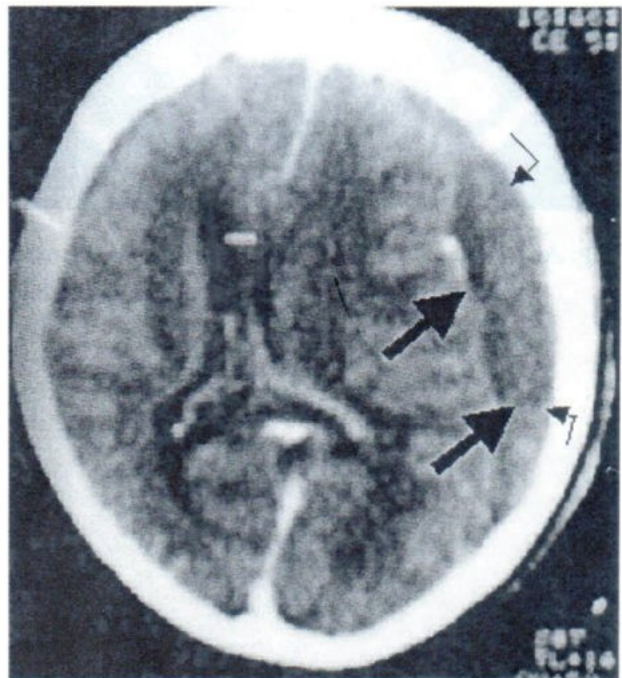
B Contrast enhanced CT.
